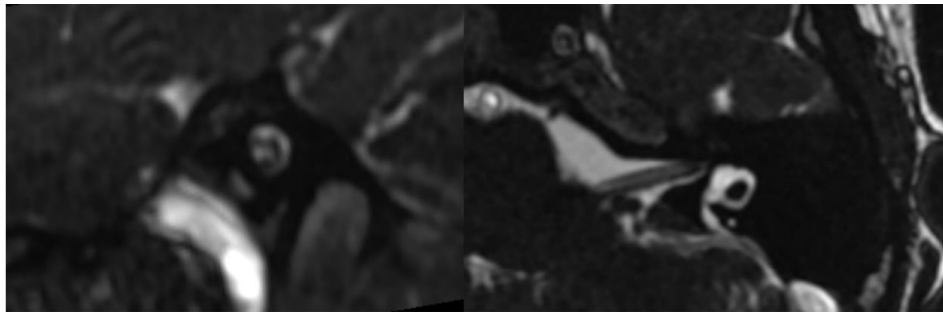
High-resolution T2-weighted MRI demonstrating preservation of the left cochlear nerve
